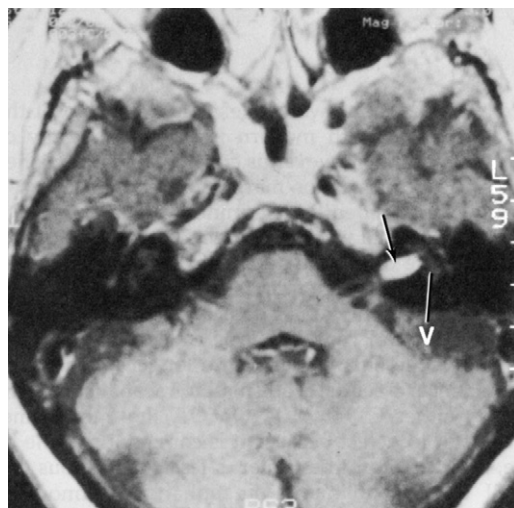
Acoustic neuroma left side (T₁-weighted gadolinium-enhanced magnetic resonance image). Small enhancing neuroma (*arrow*) is seen filling the internal auditory canal but not protruding through the porus. Compare the enhancement of the neuroma to the non-enhancing fluid in the vestibule (V).
